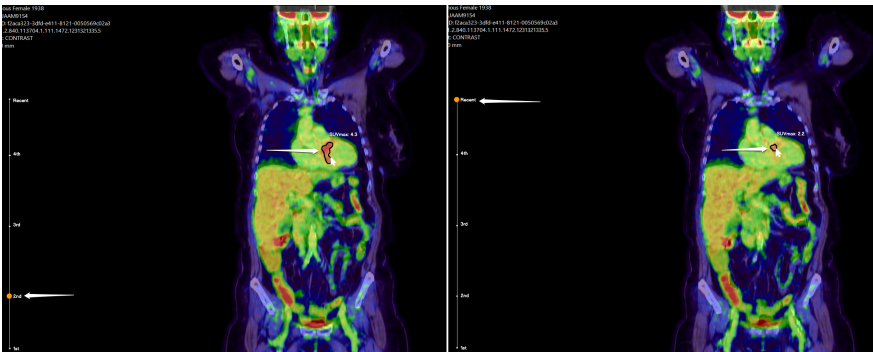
The therapy progression/regression is visualized by displaying the change in absolute SUV_{max} and the segmented area. The selected examination to be presented is depicted to the left in both images.
